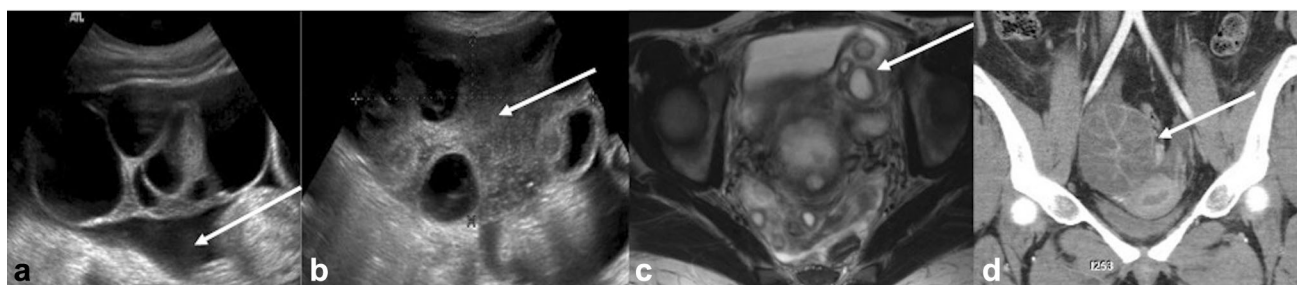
A 36-year-old woman undergoing fertility treatment who presents with abdominal pain and distention. a Transvaginal ultrasound image of the right ovary demonstrates marked enlargement with multiple cysts. Free pelvic fluid is also present. b Transvaginal ultrasound image of the left ovary demonstrates similar enlargement
